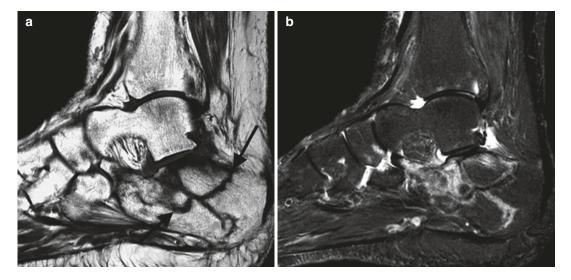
Insufficiency fractures, acute and chronic, of the calcaneus. MRI of a 69-year-old female. (a) Sag T1 and (b) T2FS with low-SI fracture lines on T1 (*black arrows*) and surrounding bone marrow edema and high SI on T2
